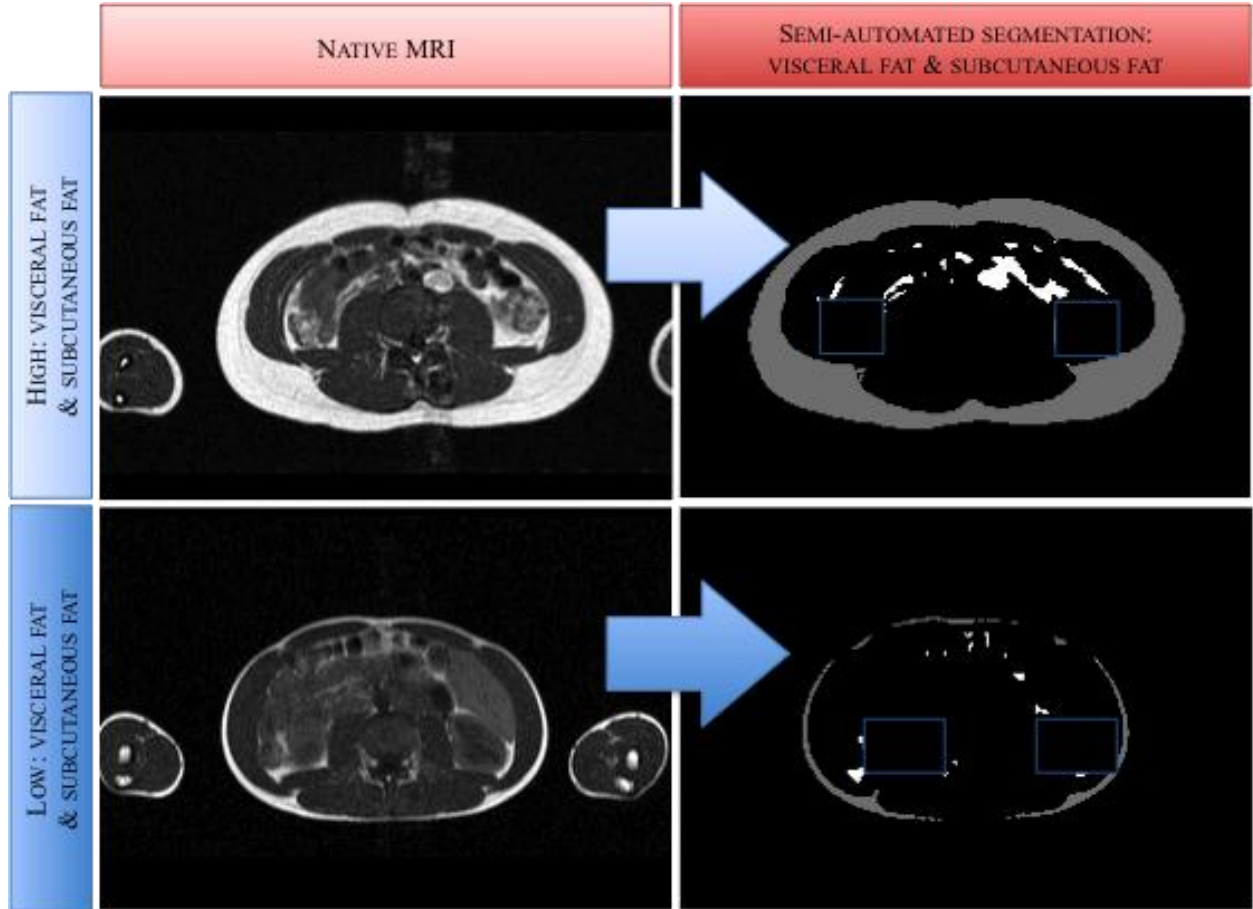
Magnetic resonance imaging and quantification of visceral *versus* subcutaneous abdominal fat.
